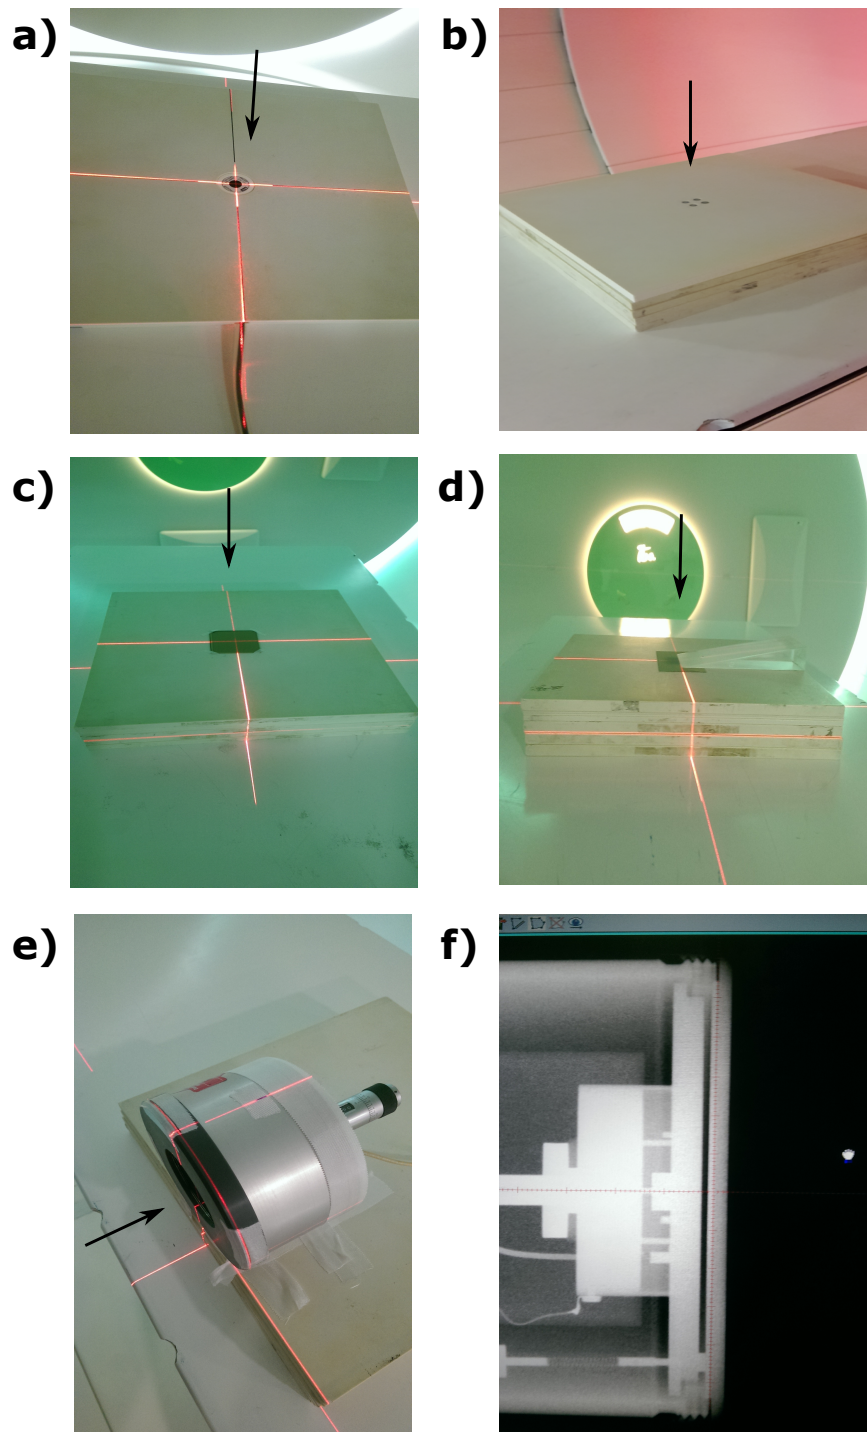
Setup of various used detectors for the determination of surface and skin dose. The direction of irradiation is marked with an arrow. a) Embedded IBA PPC05 in RW3. b) Four drilled holes for TLDs embedded in RW3 (taken from [124]). c) Alignment of Gafchromic™ EBT3 film array. d) Placement of PMMA wedge on Gafchromic™ EBT3 film. e) Setup of the PTW extrapolation IC type 23391 f) X-ray image of the PTW extrapolation IC type 23391 alignment.
